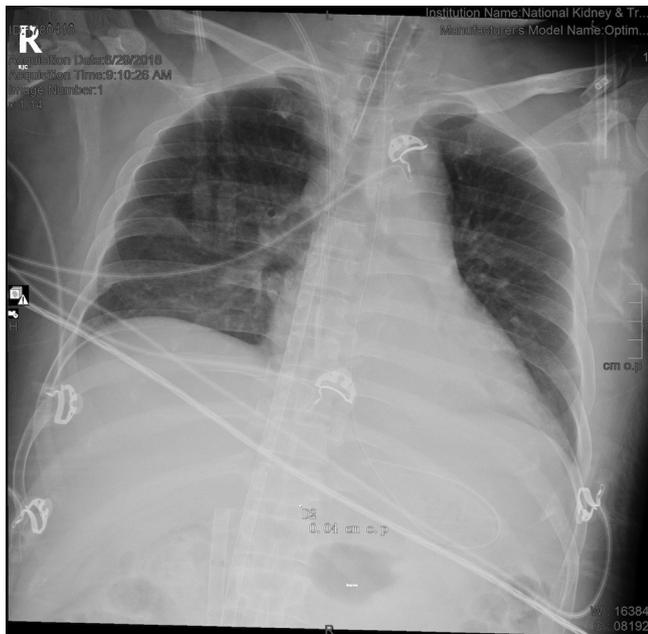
Day 5 extracorporeal membrane oxygenation chest X-ray. There is partial clearing of the hazy densities in the right lung and in the left paracardiac area.
